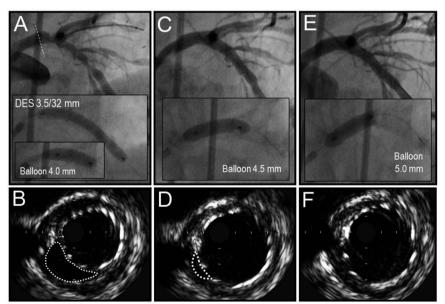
DES malapposition in the left main stem corrected by extremely oversized partial (proximal) postdilation of the DES. A) Implantation of 3.5/32mm DES with subsequent postdilation with 4.0mm balloon. B) DES malapposition in the LM stem demonstrated by intravascular ultrasound (indicated by dotted gray line). C) Postdilation with 4.5mm balloon. D) Persistence of minor malapposition. E) Postdilation with 5.0mm balloon. F) Disappearance of malapposition in the postdilated stent region.
